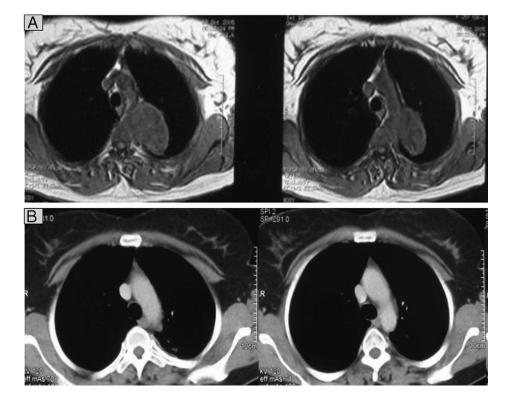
A*, Chest magnetic resonance image of a patient showing a thoracic mass that was confirmed to be a PNET (primitive neuroectodermal tumor). *B*, Chest computerized tomography image of the same patient taken after neoadjuvant chemotherapy showing total regression.
